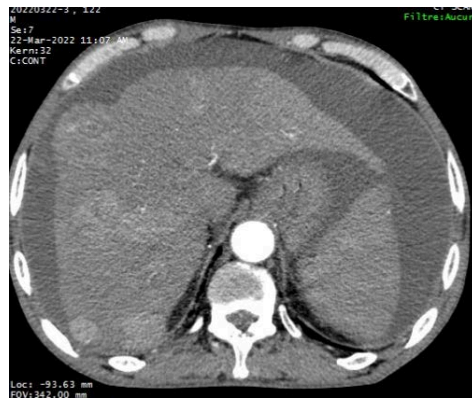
Image of the National Medical Imaging Center in Bangui. Patient, 62 years old, abdominal CT scan for exploration of ascites on cirrhosis, presence of nodules enhanced at arterial time and which deform the contours of the liver, abdominal ascites: Known hepatocellular carcinoma on cirrhotic liver.
